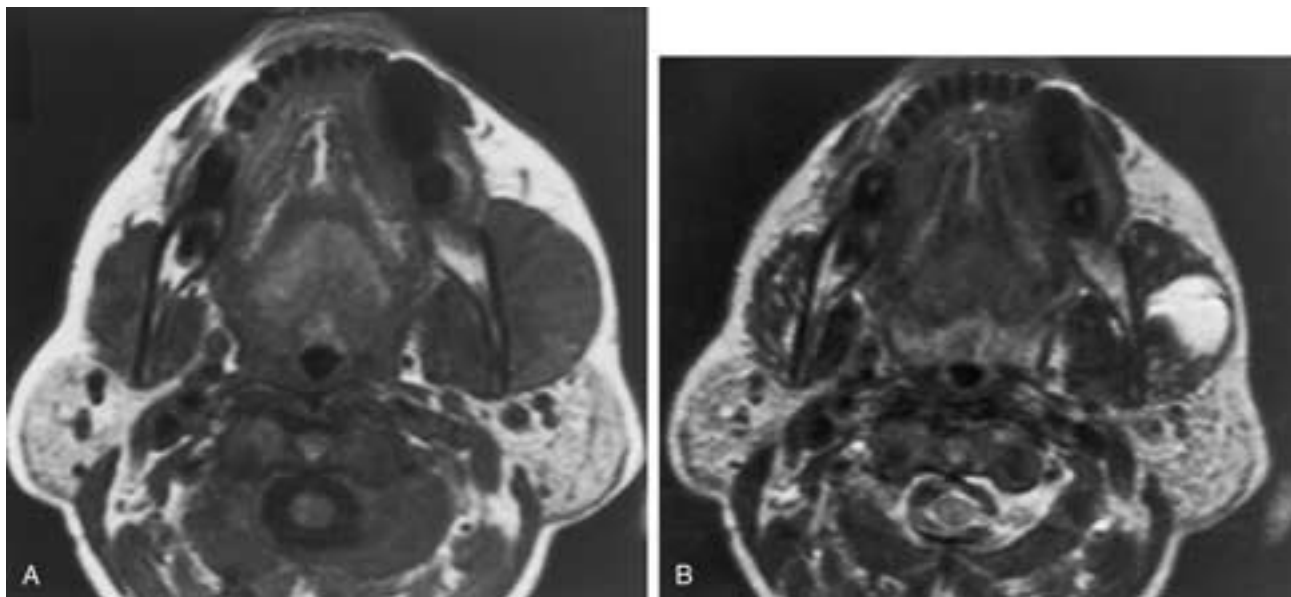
Hemangioma. (A) Axial T1-weighted and (B) axial T2-weighted MR images. Enlargement of the left masseter muscle without definition of the isointense mass is demonstrated on the T1-weighted MR image in A. The hemangioma becomes hyperintense on the T2-weighted image in B.
